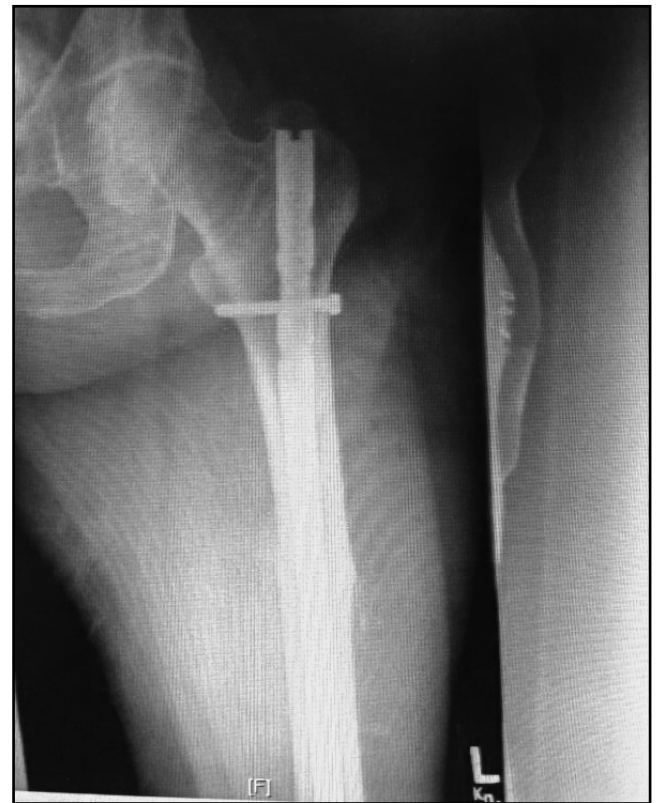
Postoperative left femur radiograph showed a good alignment of the proximal femoral fracture fragments with an indwelling intramedullary rod.
